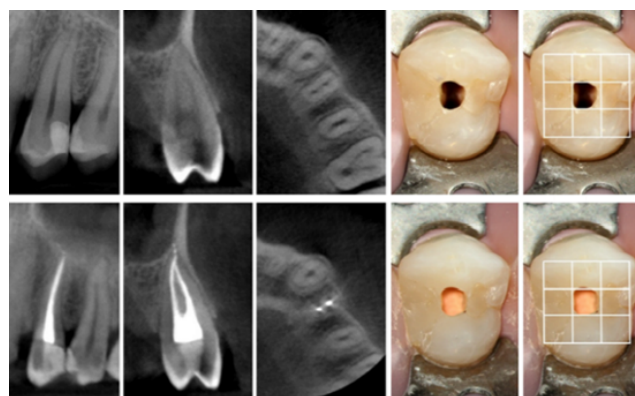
Contracted Access Cavity along with CBCTsuperimposition⁹
